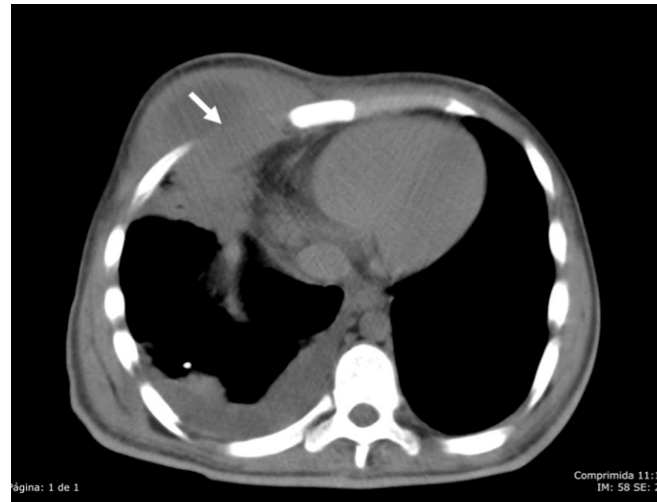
Computed tomography of the thorax. Axial section.
